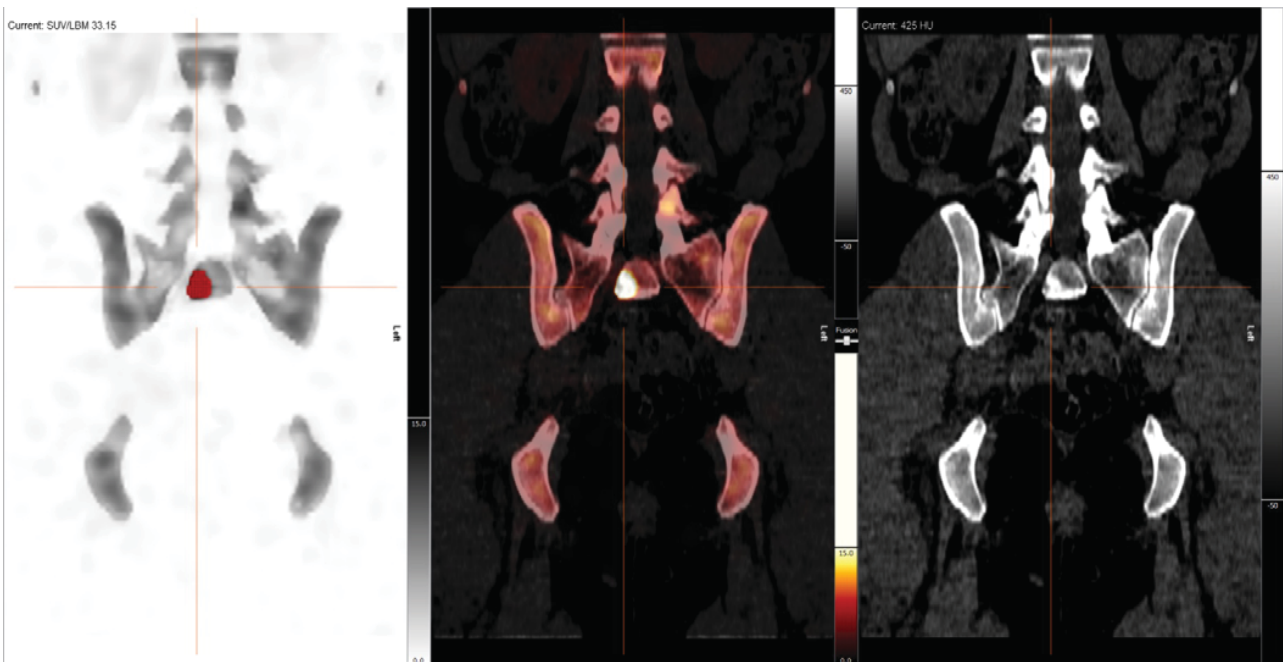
Case 1: SPECT image, SPECT/CT image and CT image (metastasis, SUV/LBM max 33.15)
